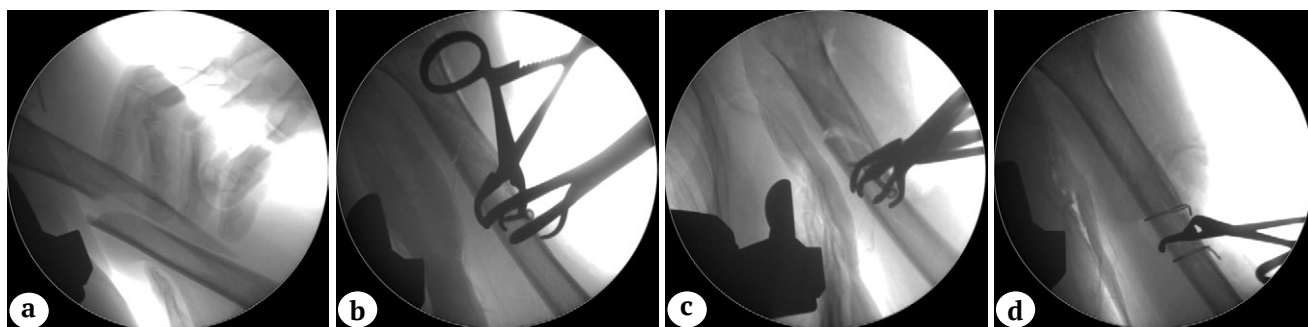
Intraoperative X-rays:
